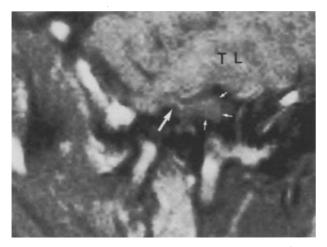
Sagittal T1-weighted, (SE 420/30) 4 mm thick, MR image *(short arrows)*. The mass initiates a signal similar to grey matter, and is continuous with the adjacent temporal lobe *(TL) (arrow)*
